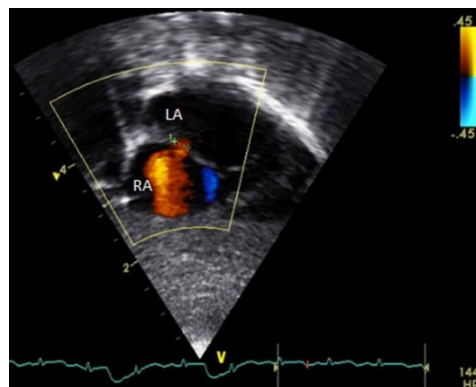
Visualization of patent foramen ovale (PFO): the volume of shunt from the LA to the RA can be clearly visualized using colour Doppler ultrasound in a neonate.
